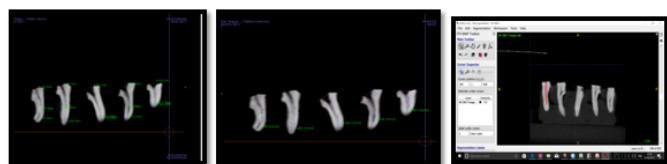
Measuring Canal Curvature, Area and Volume through CBCT software.
